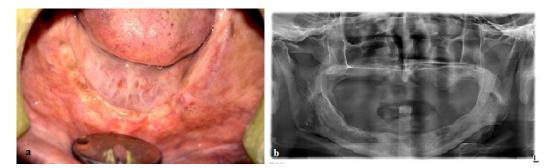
5 months postoperative photographs. Fig 3.a showing clinical photograph with corrected alveolar defect; Fig 3.b showing postoperative orthopantomogram showing newly formed bone in the grafted area
